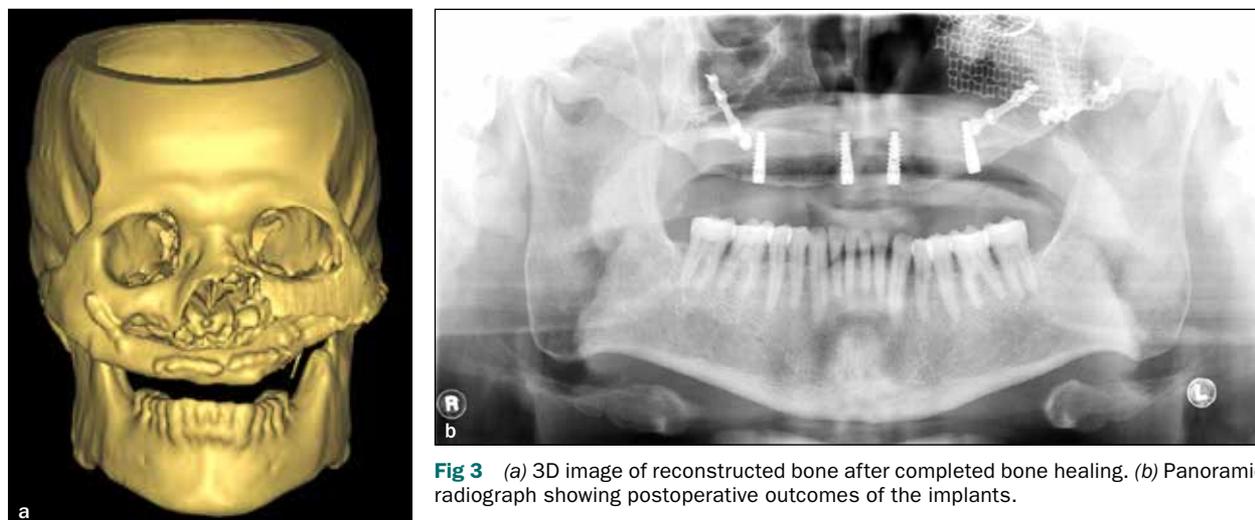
(a) 3D image of reconstructed bone after completed bone healing. (b) Panoramic radiograph showing postoperative outcomes of the implants.
